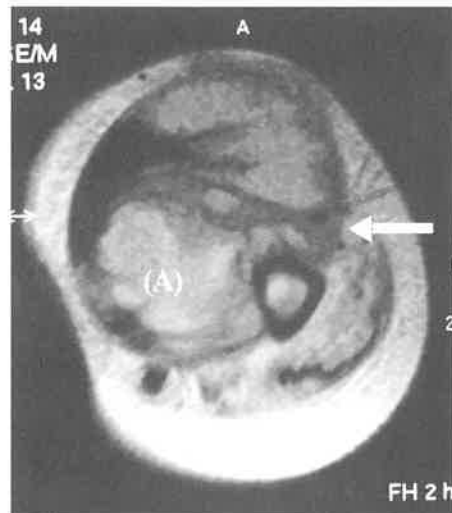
MRI image of intramuscular abscess (A) compressing the radial nerve (arrow).
